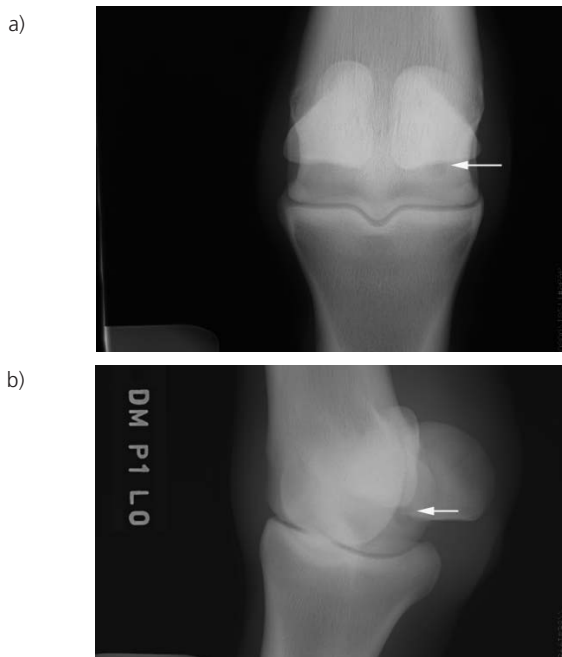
Dorsopalmar (a) and dorsomedial to palmarolateral oblique (b) radiographic images of the left metacarpophalangeal joint obtained after nuclear scintigraphy. Note the radiolucency in the palmar medial third metacarpal condyle.
